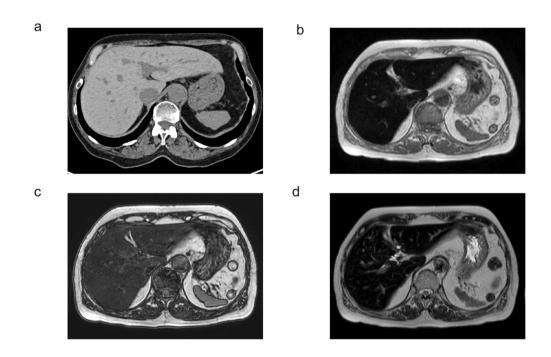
Computed tomography (CT) and magnetic resonance imaging of the patient, a 69-year-old woman with type 3 hereditary hemochromatosis. (a) CT showed hyperattenuation of the liver parenchyma values. T1-weighted image showed a decrease in signal intensity in the in-phase (b) compared to the opposed-phase (c), indicating iron overload. (d) T2 star-weighted images showed diffuse hypointensity of the liver parenchyma.
